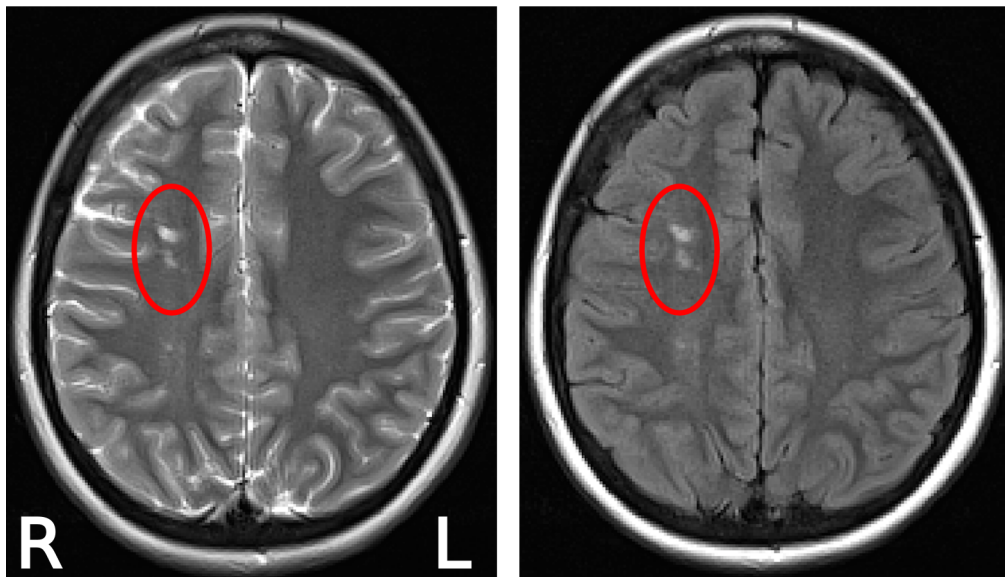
An example of right frontal silent cerebral infarcts in a 14-year-old male with HbSS. Both T2-weighted image (left) and fluid-attenuated inversion recovery (FLAIR, right) image show hyperintense signal corresponding to the lesion site.
